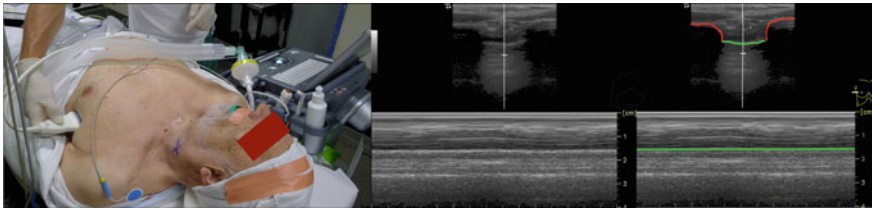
Lung sliding. *Left* The ultrasound probe is placed transversely in an inter-space between two ribs during normal ventilation. *Middle* The scanning image, *upper* B-mode scan, *lower* M-(Motion)-mode. *Right* The *green line* indicates the *pleural line*. The *red lines* indicate the anterior surface of 2 ribs behind which shadowing is seen. Note that the outline of the ribs and the pleural line forms the image of a flying bat = the “bat sign” demonstrating that 2 ribs are involved which is necessary in order to identify the pleural line among the many *white lines*. Note that in the M-mode image it is easy to distinguish the non-moving tissue above the *pleural line* from the artifact created from the respiratory movement of the visceral pleura relative to the parietal pleura. This is called the “sea shore sign” or the “sandy beach sign” because the non-moving part resembles waves and the artifact pattern below resembles a sandy beach
